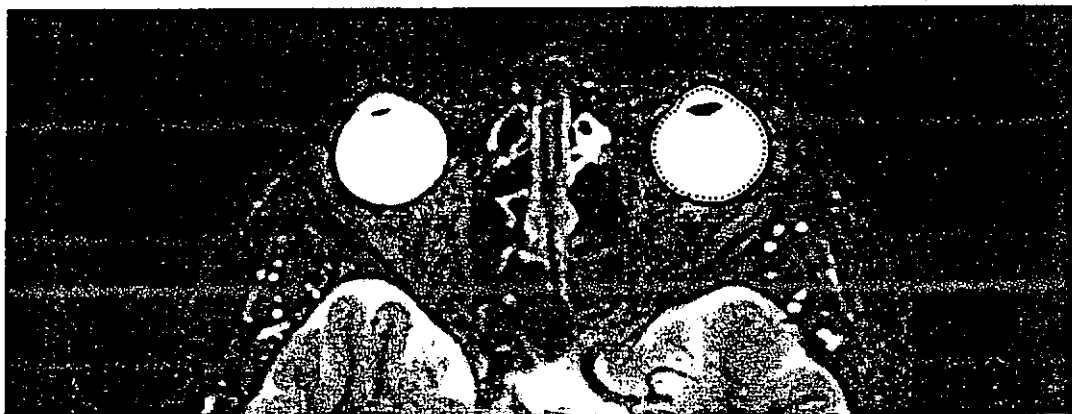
ROI was determined automatically by the seed growing segmentation technique on the left eyeball on an axial T2-weighted MRI orbit image.
